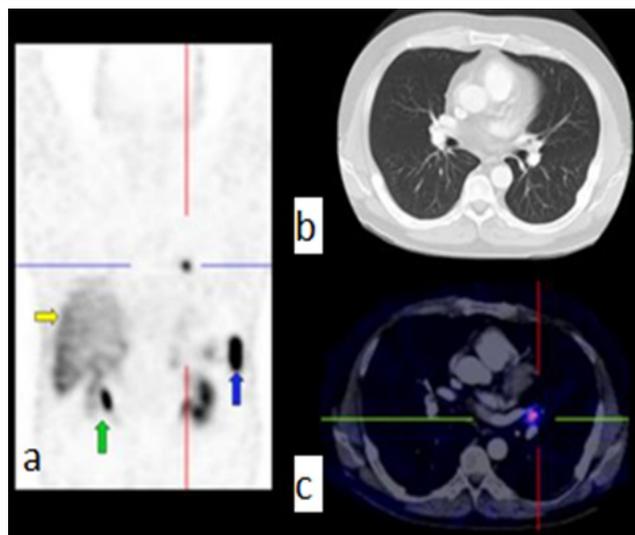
99mTc-HYNIC-TOC somatostatin receptor scintigraphy.
